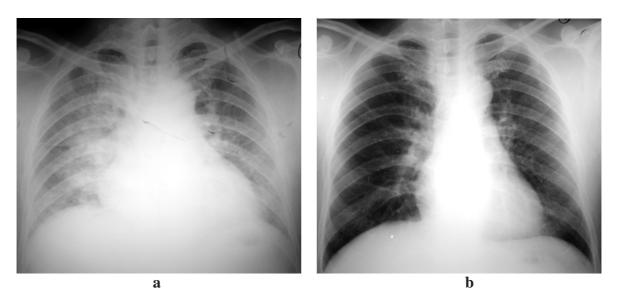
Chest radiographs: a) initial film showed cardiomegaly with congestive heart failure pattern b) early follow-up film, findings were resolved
